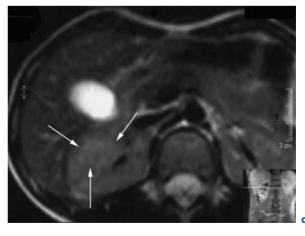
Metanephric adenoma in a 7-year-old boy. CT scan (unenhanced, a; enhanced, b) shows a spontaneously hyperdense small mass. On MR T2-W images (c) the lesion is almost isointense to the normal parenchyma (courtesy Dr. C. Treguier, Hôpital de Pontchaillou, Rennes, France)
